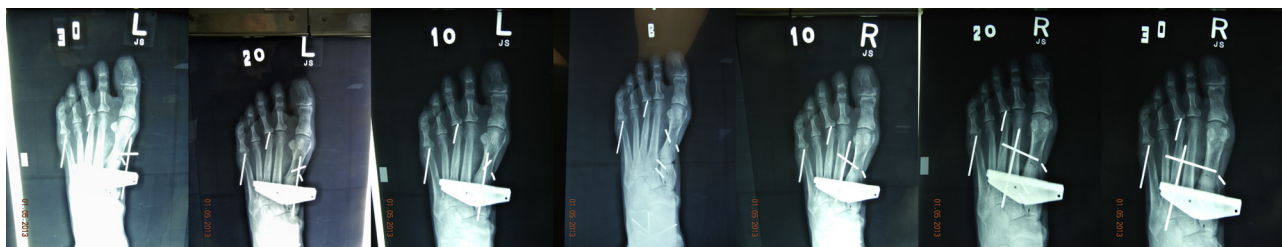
Radiographic images showing rotation from the original baseline image (B),  $10^\circ$  valgus (10 L),  $20^\circ$  valgus (20 L),  $30^\circ$  valgus (30 L),  $10^\circ$  varus (10 R),  $20^\circ$  varus (20 R), and  $30^\circ$  varus (30 R).
